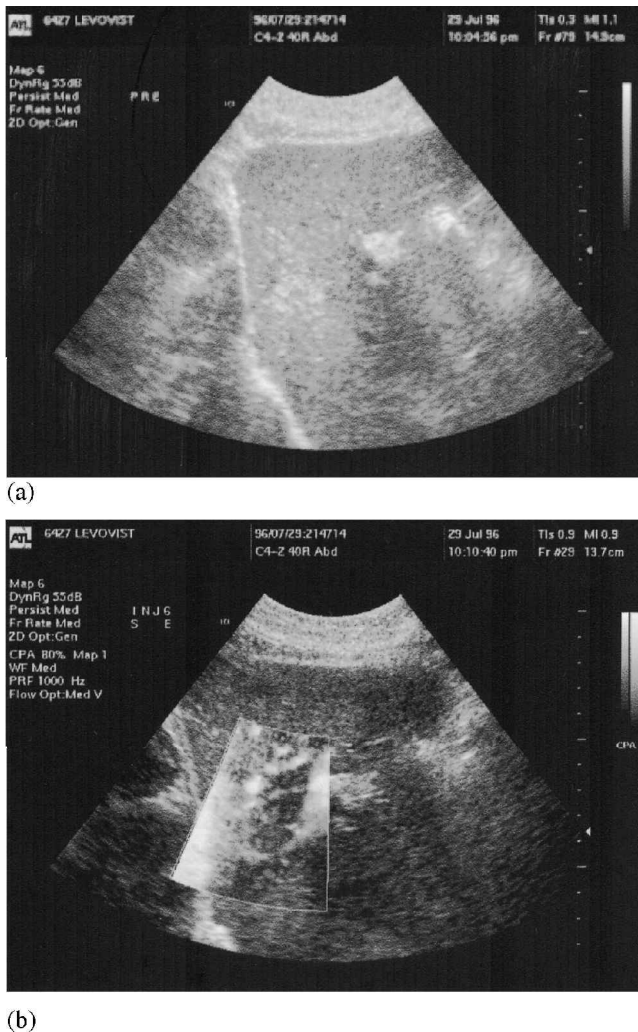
Ultrasound image of a neuroendocrine tumour in the liver (a) before and (b) after contrast enhancement in power Doppler mode (photographs courtesy of Professor Peter Dawson)
